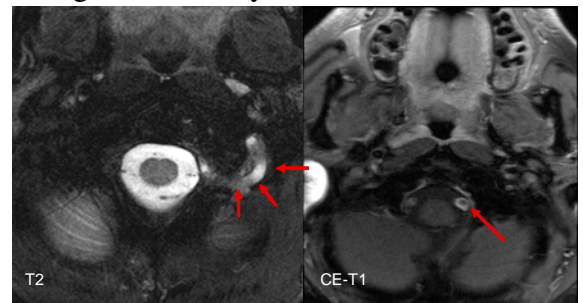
47 year old subject with a history of left cerebellar infarction and an arterial dissection the left vertebral artery. T1-weighted contrast enhanced images show strong contrast uptake in the dissection left vertebral artery, indicating focal arteritis. T2-weighted images show the hematoma of the arterial wall.
